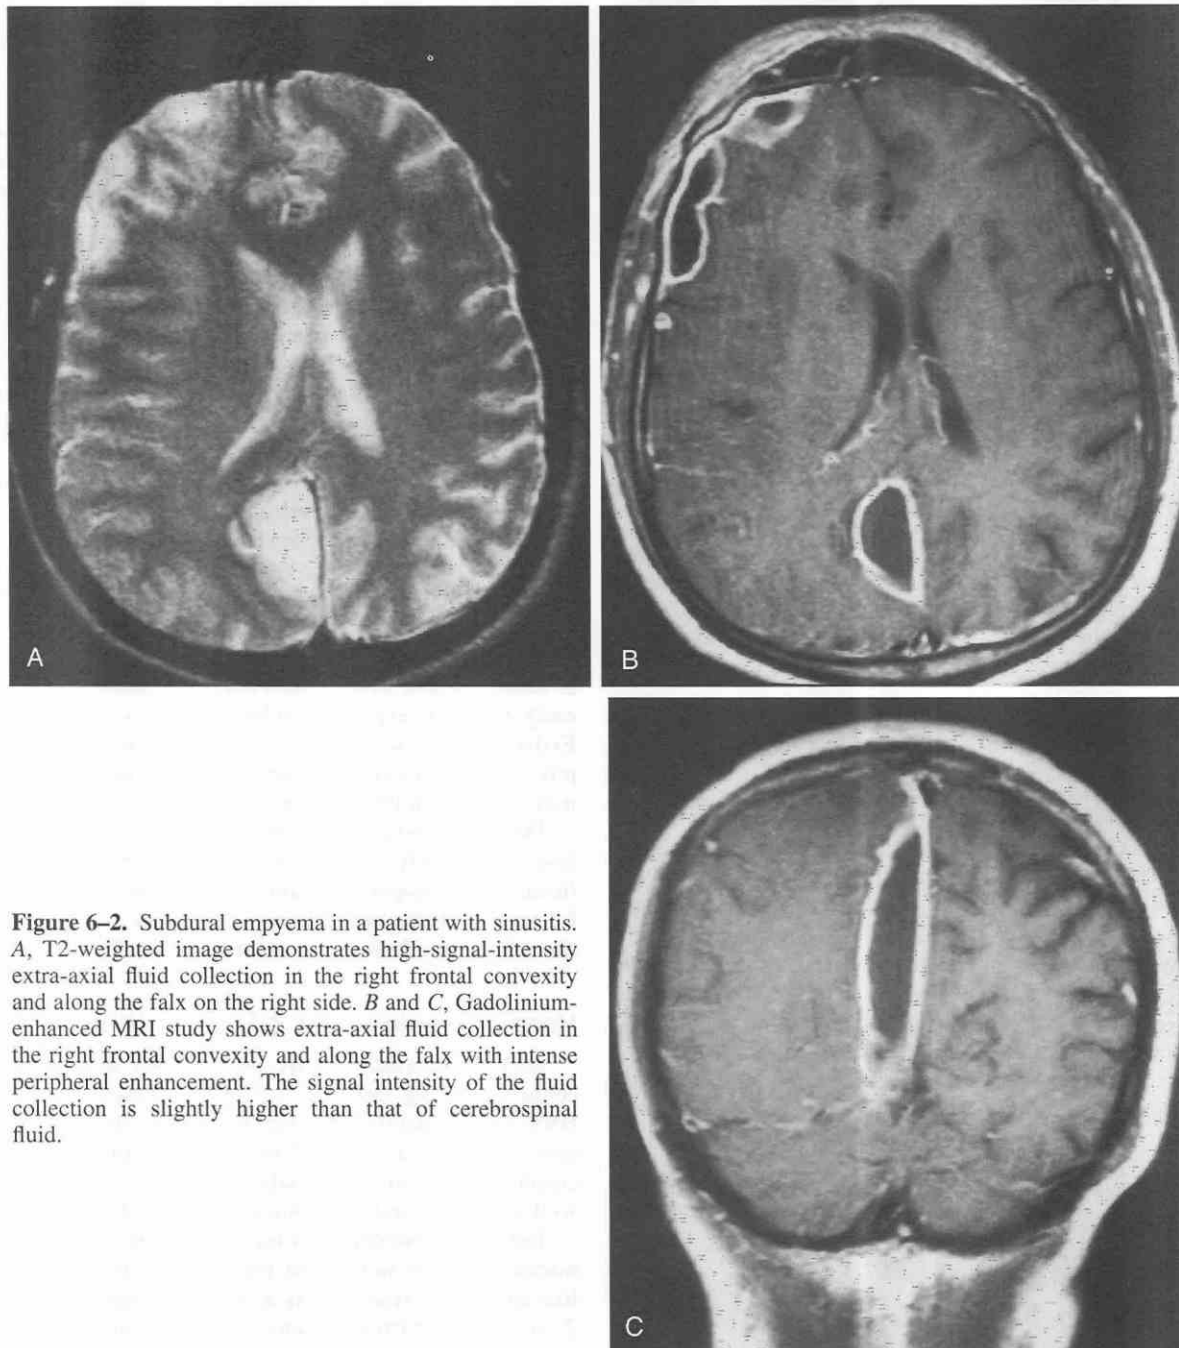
Subdural empyema in a patient with sinusitis. *A*, T2-weighted image demonstrates high-signal-intensity extra-axial fluid collection in the right frontal convexity and along the falx on the right side. *B* and *C*, Gadolinium-enhanced MRI study shows extra-axial fluid collection in the right frontal convexity and along the falx with intense peripheral enhancement. The signal intensity of the fluid collection is slightly higher than that of cerebrospinal fluid.
